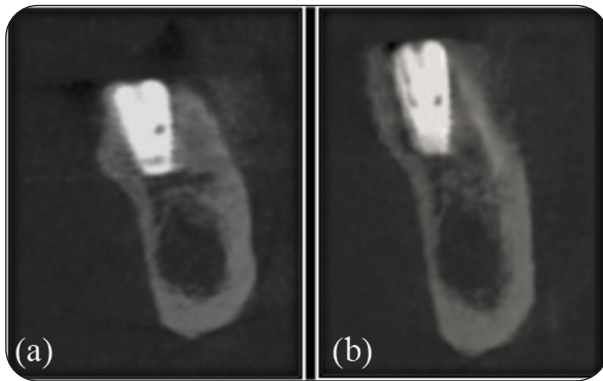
Radiographic photos showing implants (a) implant after allogenic bone block, (b) implant after piezosplitting with allogenic bone chips.
